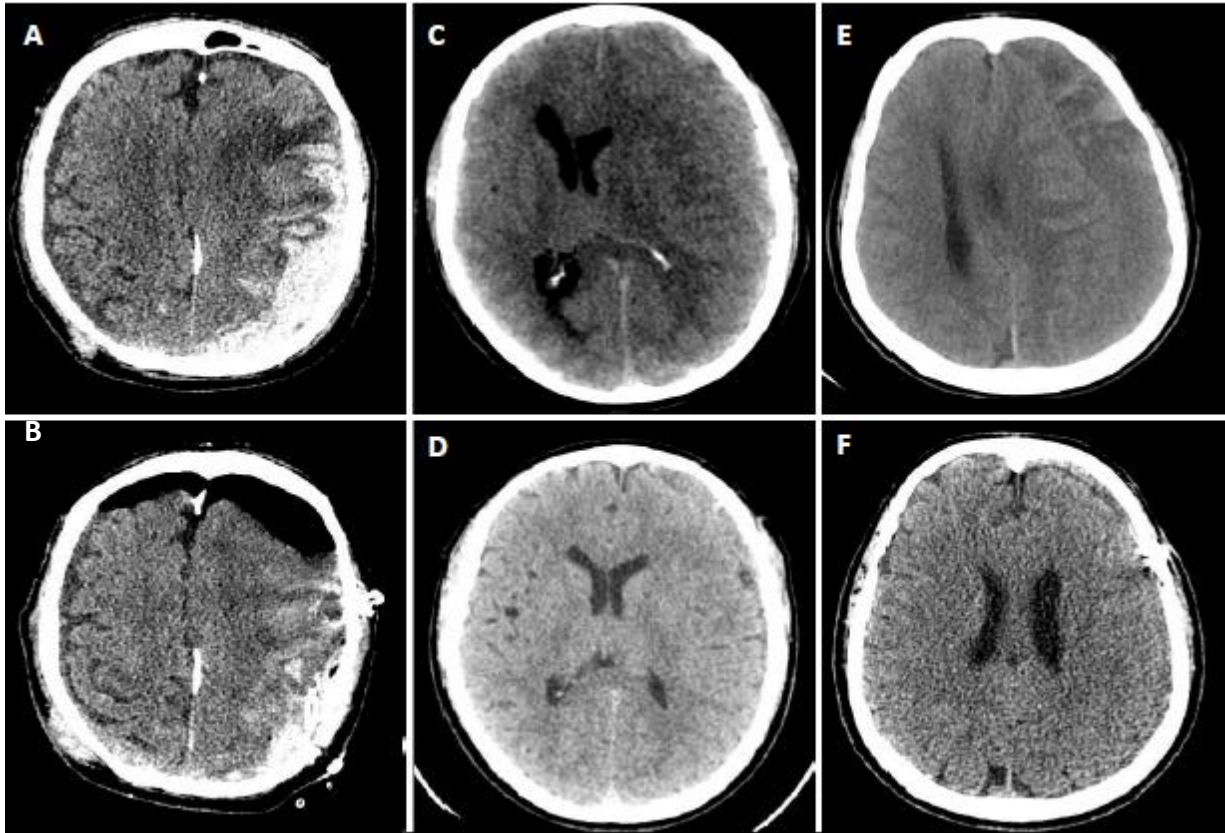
Preoperative (A) and postoperative (B) CT of a patient with an acute subdural hematoma. Presence of postoperative pneumocephalus; no irrigation was used during the procedure, and the Mount Fuji sign is seen in the postoperative CT. Preoperative (C) and postoperative (D) CT of a patient with a subacute subdural hematoma. No pneumocephalus was present using saline irrigation in this case. Preoperative (E) and postoperative (F) CT of a patient with chronic subdural hematoma; irrigation was used in this case and no pneumocephalus was seen in the postoperative CT.
